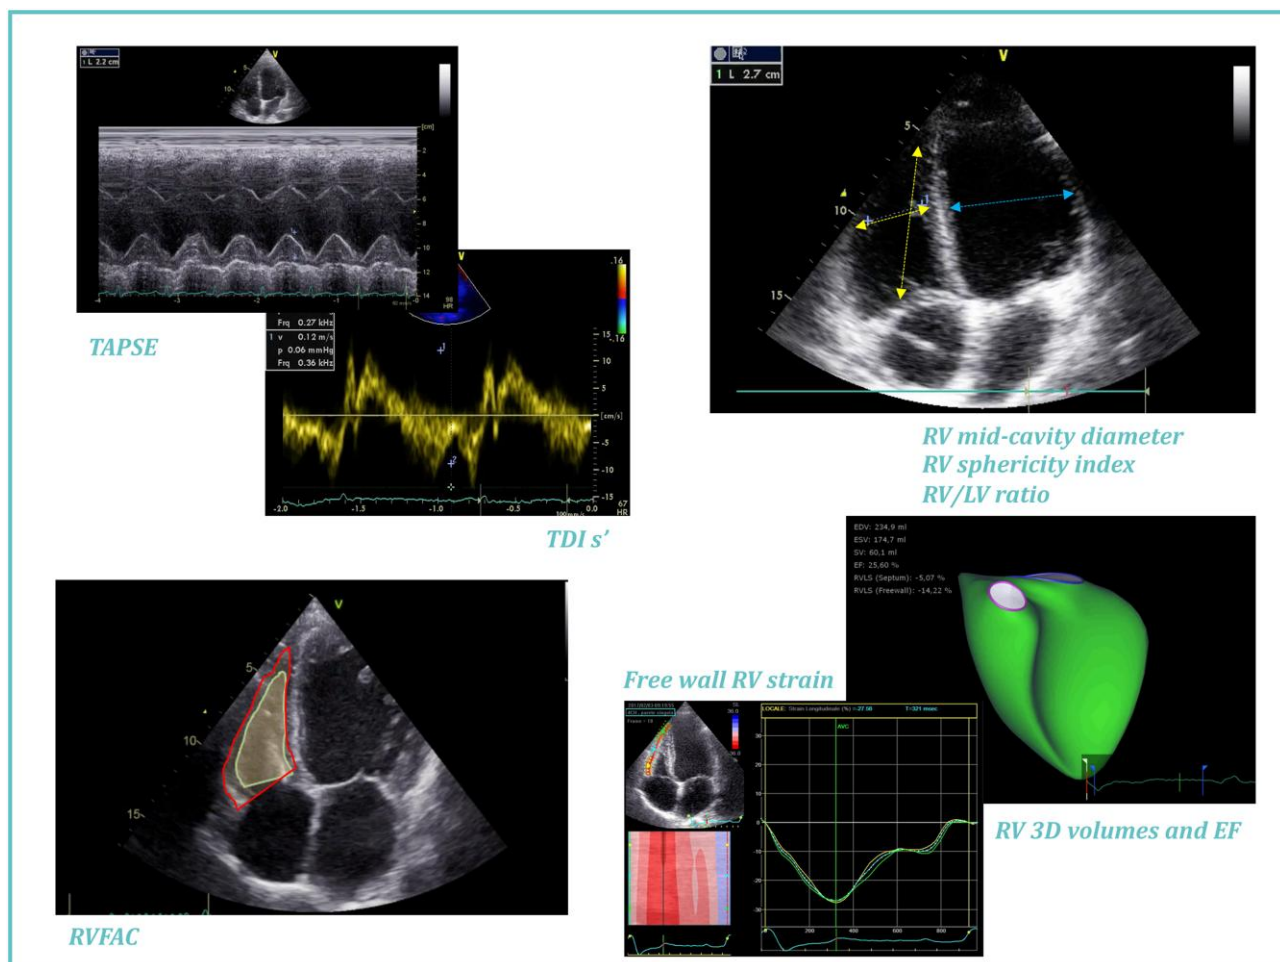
Echocardiographic evaluation of RV function. Yellow arrows indicate how to measure RV diameters, blue arrow indicate how to measure LV diameter in 4 chamber view to calculate RV/LV ratio. LV, left ventricle; RV, right ventricular; RVFAC, right ventricular fractional area change; TAPSE, tricuspid annular plane systolic excursion; TDI, tissue Doppler imaging.
